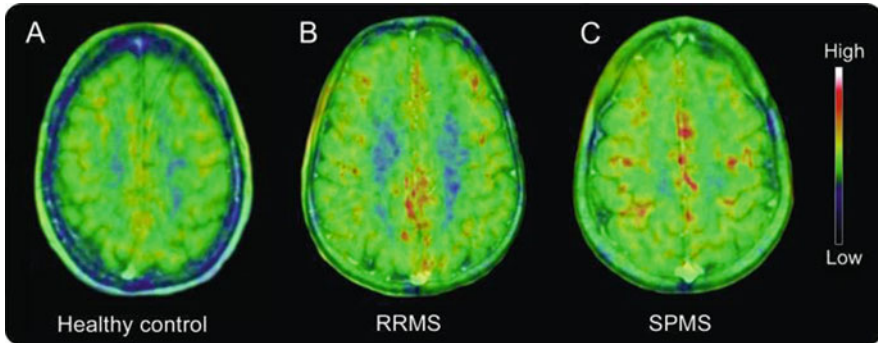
PET imaging of TSPO in multiple sclerosis. Summed [^{11}C]PK11195 PET images co-registered and fused with 1.5 T MRI at the cortical level for (a) a healthy 40-year-old woman (cortical GM PK BP_{ND}: 0.061); (b) a 46-year-old man with a 12-year history of relapsing-remitting multiple sclerosis (RRMS) (cortical GM PK BP_{ND}: 0.121); and (c) a 46-year-old woman with secondary progressive multiple sclerosis (SPMS) (cortical GM PK BP_{ND}: 0.198). GM PK BP_{ND}: gray matter [^{11}C]PK11195 binding potential of the specifically bound radioligand relative to the nondisplaceable radioligand in tissue. Adapted from Politis et al. [78]. © 2012, American Academy of Neurology
